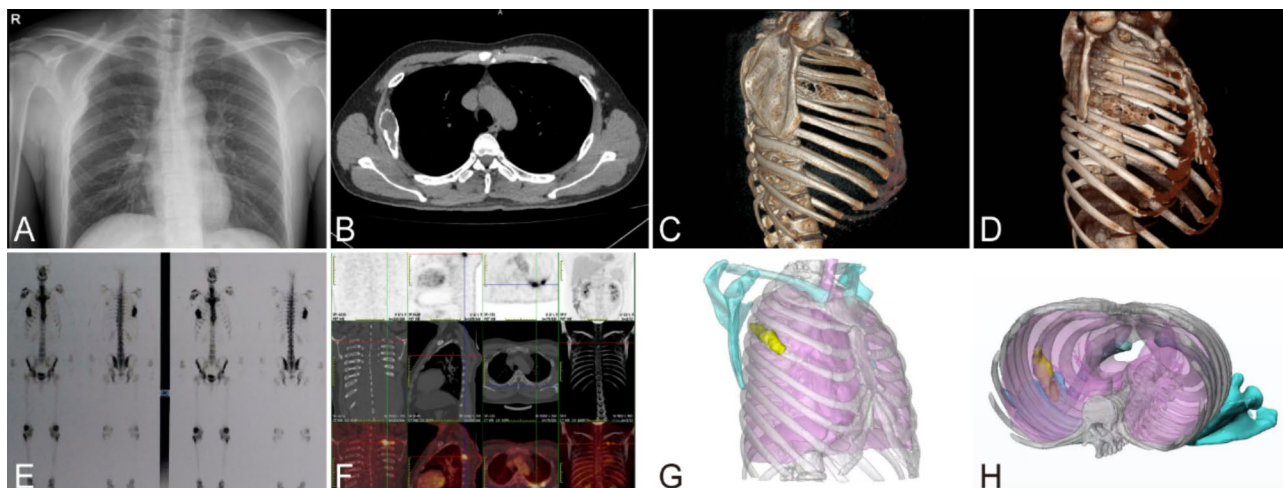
Preoperative imaging examinations and 3D images of some patients. (A) Chest radiography shows a lesion in the right chest wall. (B) Chest CT revealed a fusiform lesion with ground-glass centre of the lateral aspect of the right 4th rib. (C, D) 3D reconstructions show two lesions of FD in the right 4th rib and the right 5th rib respectively. (E) Bone scan shows increased activity in the right 5th rib. (F) PET-CT shows a benign costal lesion of the post aspect of the left 4th rib in a patient with breast cancer. (G, H) 3D images reconstructed with Mimics Meccical 21.0 software. Exact three-dimensional relationships of the rib tumor, upper and lower ribs, blood vessels, spines and pulmonary tissues. Grey: normal ribs and spines; Purple: pulmonary tissues; Blue: scapulas and clavicles; Yellow: rib tumor region
